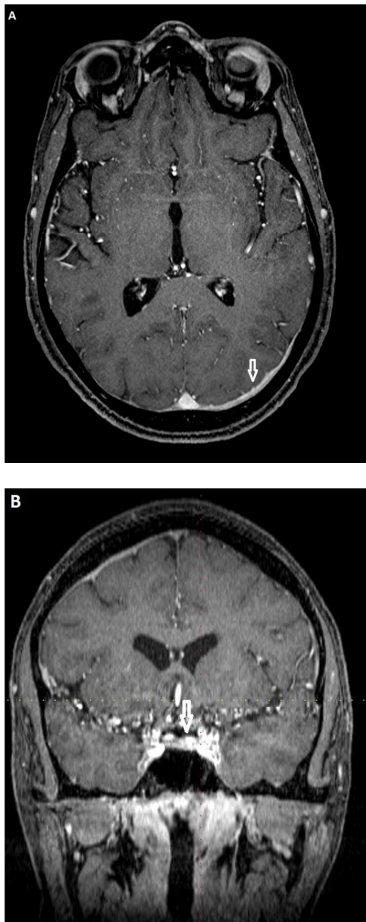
MRI of the brain showing significant leptomeningeal enhancement in the left parietal-occipital region (A) and posterior fossa (B). No abnormal enhancement of the orbit or optic nerves.
